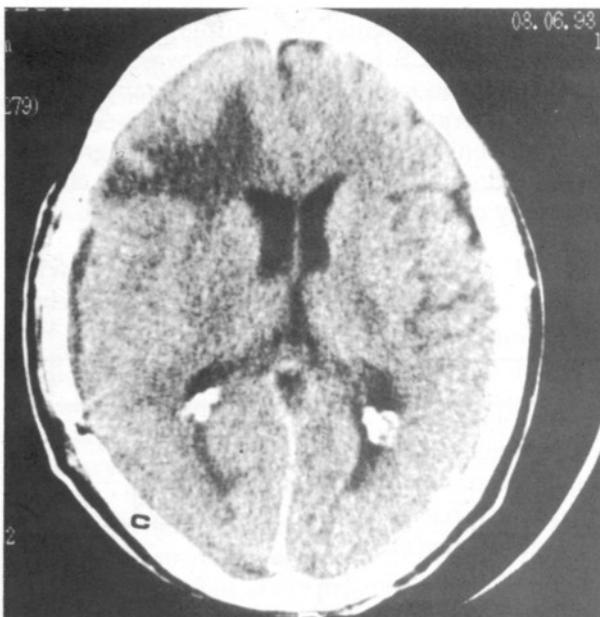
Computed tomography scan of a patient with hemispheric swelling and acute subdural hematoma not requiring surgery.
